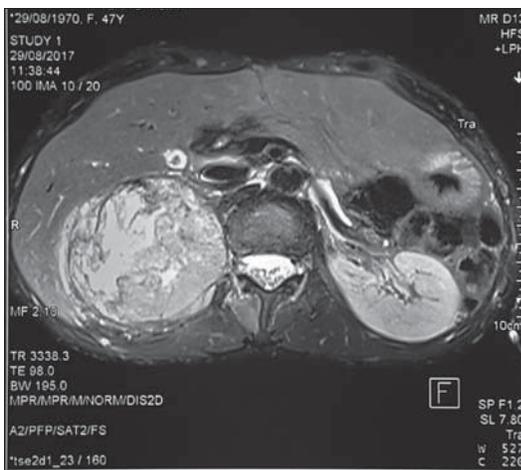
MRI showing the right adrenal masses.
